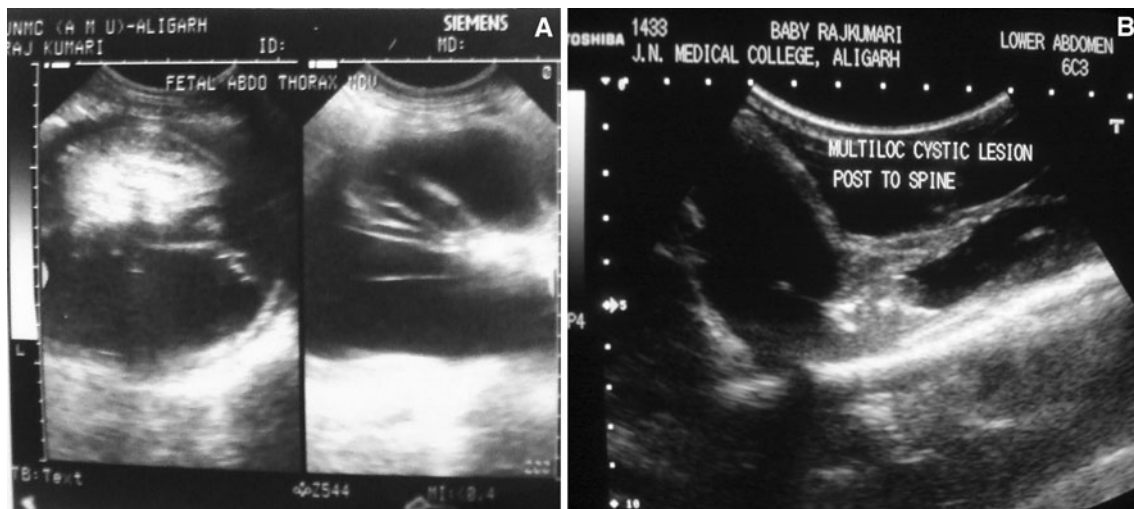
a, b Antenatal ultrasound scan shows malformed twin showing parts of spine and large cystic spaces in the torso; these
